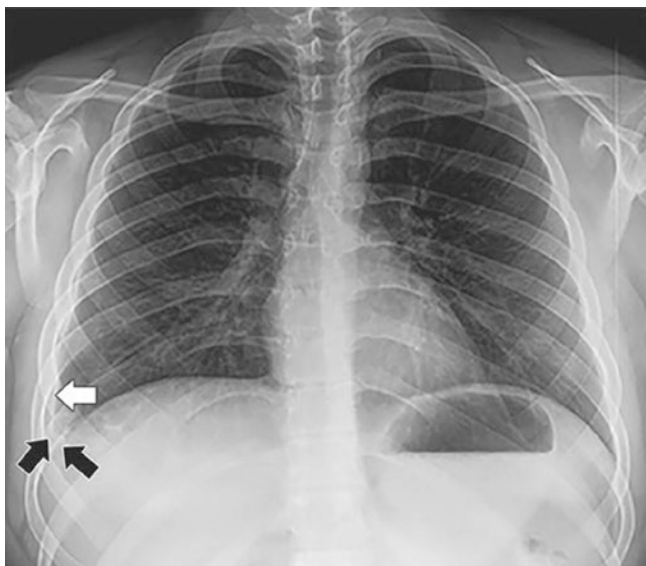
A 17-year-old boy with prolonged immobilization after a motor vehicle collision, with acute onset of tachycardia. Frontal radiograph shows small right pleural effusion (white arrow) and pleural-based opacity (black arrow) in the right costophrenic angle, with triangular opacity, with superomedial margin pointing toward the hilum (Hampton hump), representing small pulmonary infarct. (Reprint with permission from Lee et al. [9])
